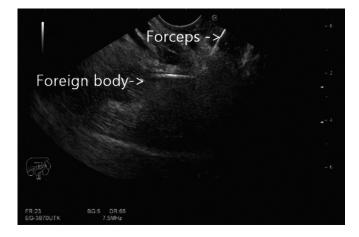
Ultrasonographic image showing foreign body insinuating itself into the stomach after traction with forceps.
